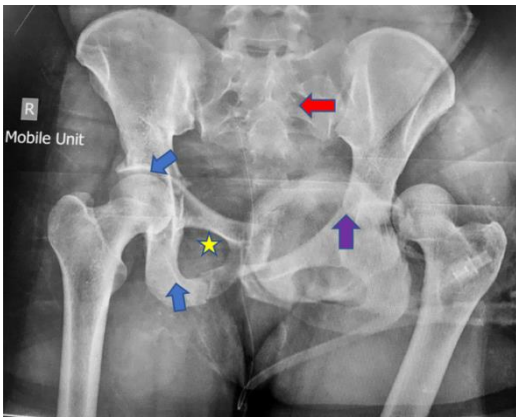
Figure VI (Case two): Emergency room anteroposterior screening pelvic X-ray showing a lateral compression type injury with right-sided superior and inferior pubic ramus fractures (blue arrows), complete pubic symphysis overlapping dislocation (yellow star), and contra-lateral sacroiliac joint disruption (red arrow). A left posterior hip dislocation with associated superior pubic ramus and posterior acetabular wall fractures were also noted (purple arrow).
